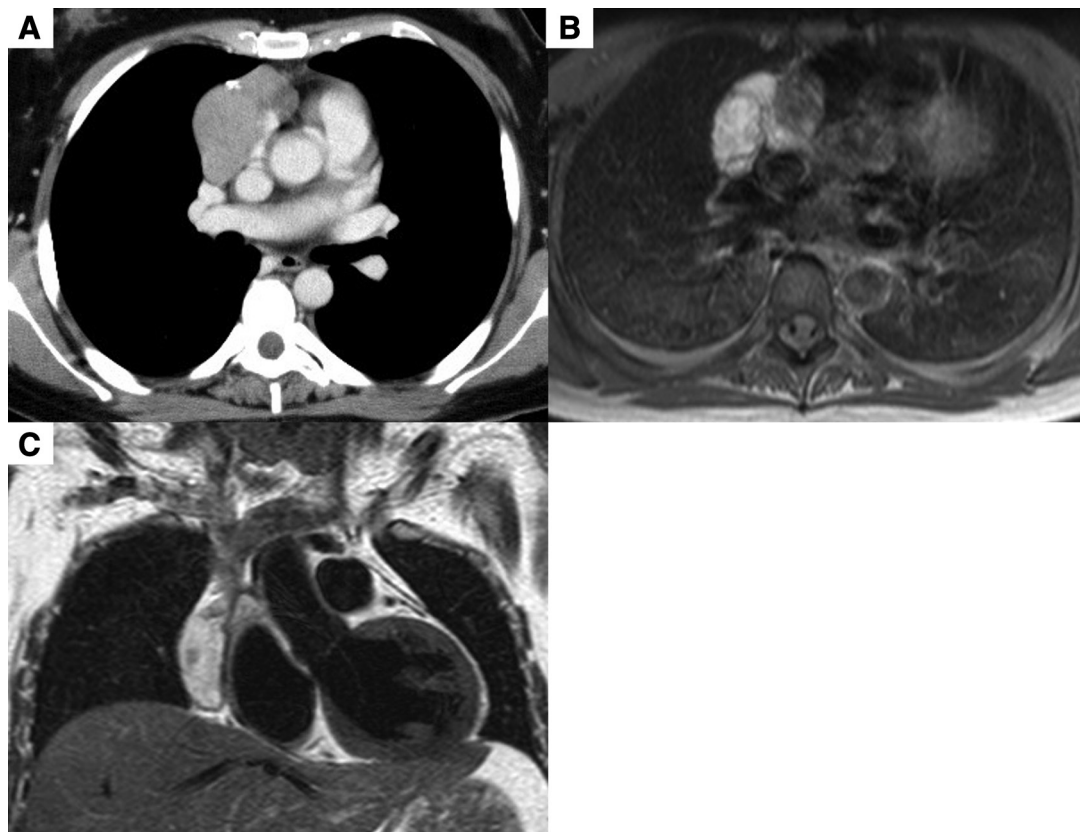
Computed tomography showing a 6.0 × 4.0 cm mass with uneven contrast effect and calcification in anterior mediastinal (A). MRI showing the mass adjacent to the pericardium and lung, but the mass is covered by film, indicating no obvious invasion (B and C). MRI: magnetic resonance imaging
